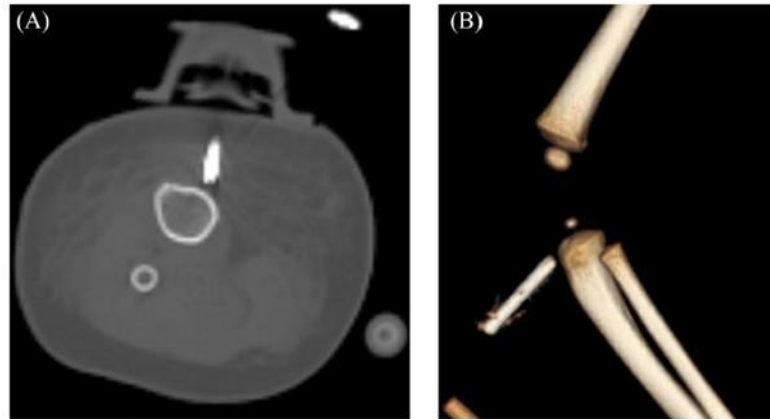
Unsuccessful needle placement in a 2-month-old female. (A) Axial CT of the proximal right tibia shows the needle tip to be in soft tissue medial to the bone. The needle length measured as 15 mm. (B) 3D reconstruction shows the level and direction of the needle.
